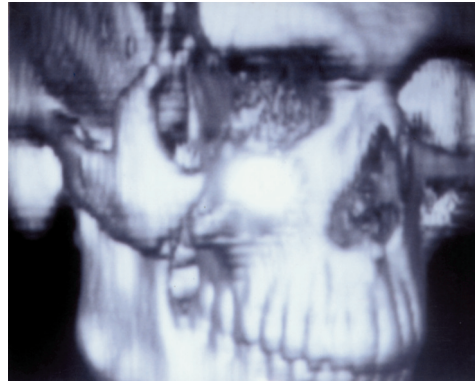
Tridimensional CT showing fractures of the floor and lateral wall of the right orbit.
